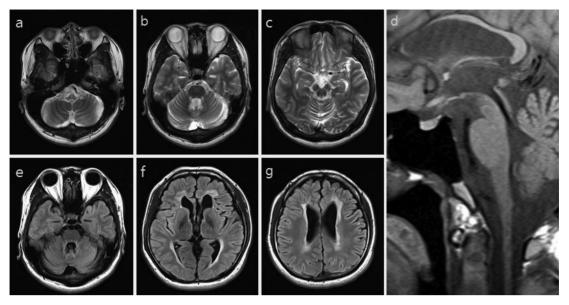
T2-weighted axial images showing marked atrophy of the medulla (a) but little atrophy of the pontine base (b) and atrophy of the midbrain (c), T1-weighted sagittal images showing tadpole-like brainstem atrophy with cerebellar atrophy and thinning of the anterior body of the corpus callosum (d) FLAIR axial images showing abnormal hyperintensities around the fourth ventricle (e) and bilateral periventricular white matter (f, g)
